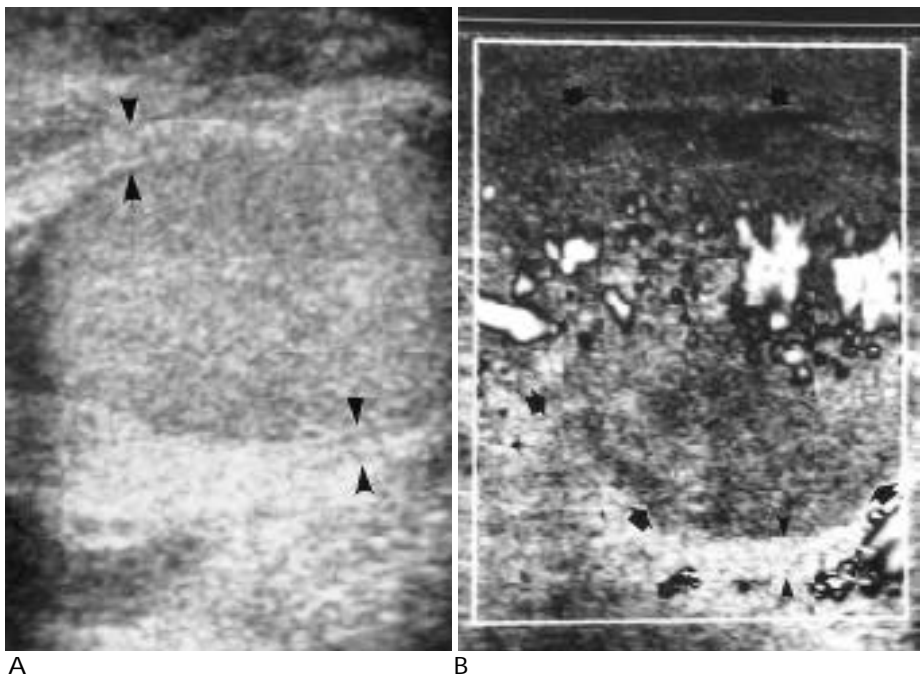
A. Longitudinal scan of scrotal ultrasonography demonstrates a normal right testis with mild thickening of right scrotal wall (arrowheads). B. Transverse scan of power Doppler ultrasonography of the right scrotum shows a mixed echogenic scrotal mass (black arrows) abutting on but separate from, the right testis. The mass has heterogeneous echogenicity with blood flow signals in its solid portions. Note the associated thickening of the right scrotal wall (black arrowheads).
